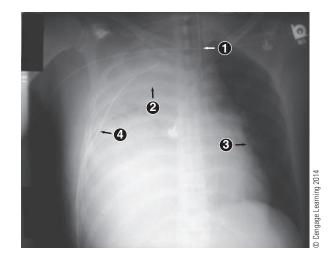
Tension hemopneumothorax. Right-sided hemopneumothorax shifts the mediastinum and trachea (1) to the left. The shift is not significant, possibly due to patient rotation when the radiograph was taken. The white area (2) on the radiograph is caused by the blood in pleural space. (*Note: air in pleural space would appear dark.*) Compression of the left lung is noted (3). Chest tube (4) can be seen on the right side.
